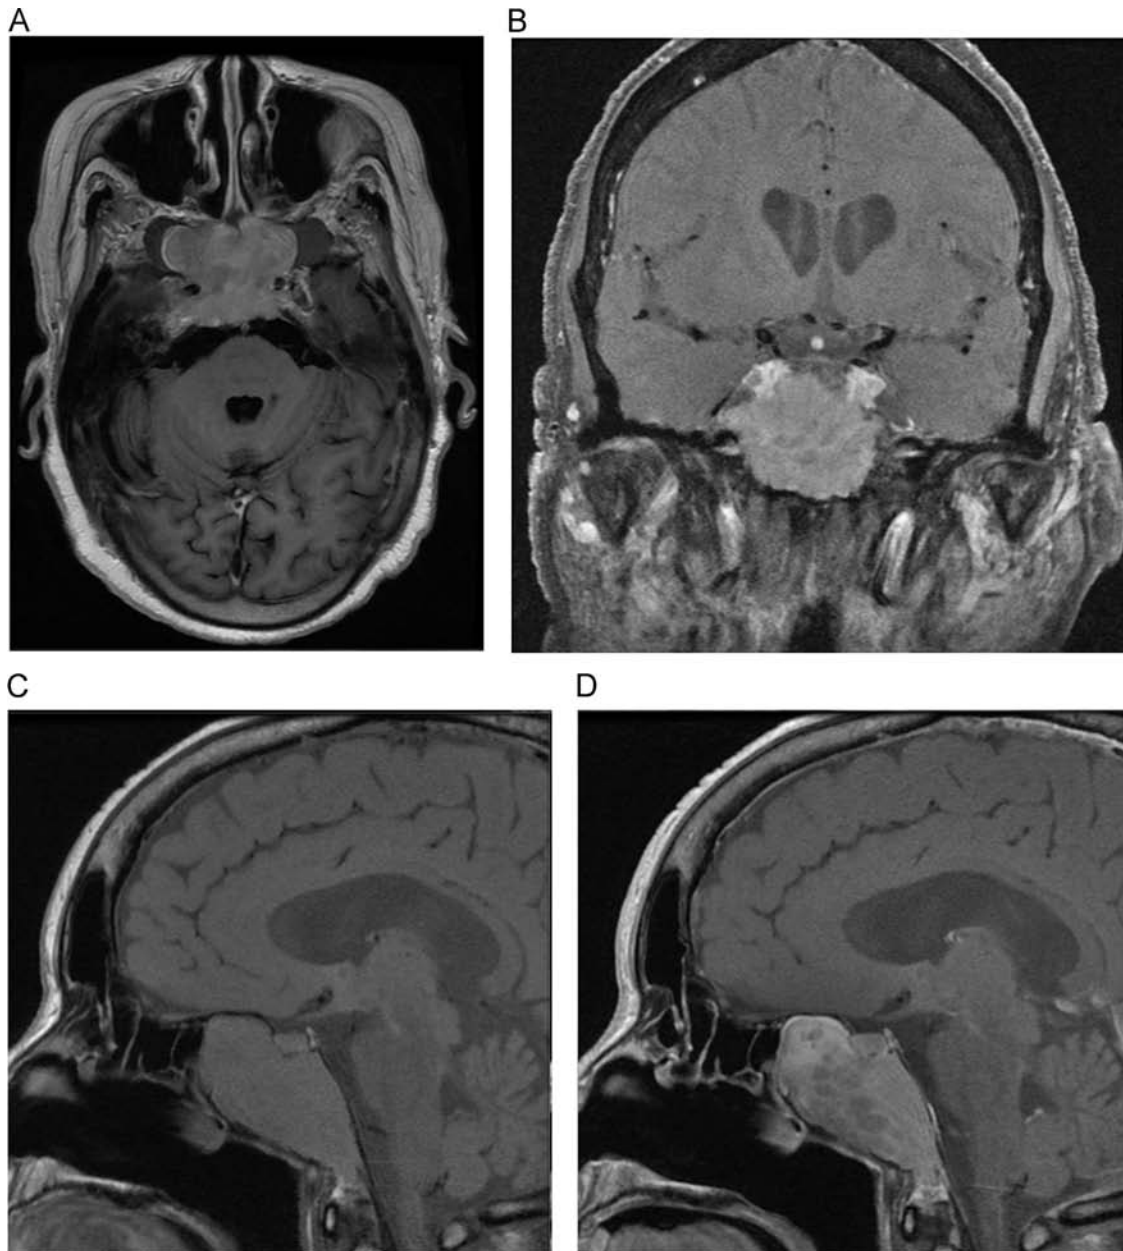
Magnetic resonance imaging of clival plasmacytoma, case 2. Images show the large heterogeneously enhancing clival mass with greater involvement of the left than right cavernous sinuses. T1 axial postcontrast (A), coronal postcontrast (B), sagittal precontrast (C), and sagittal postcontrast (D).
